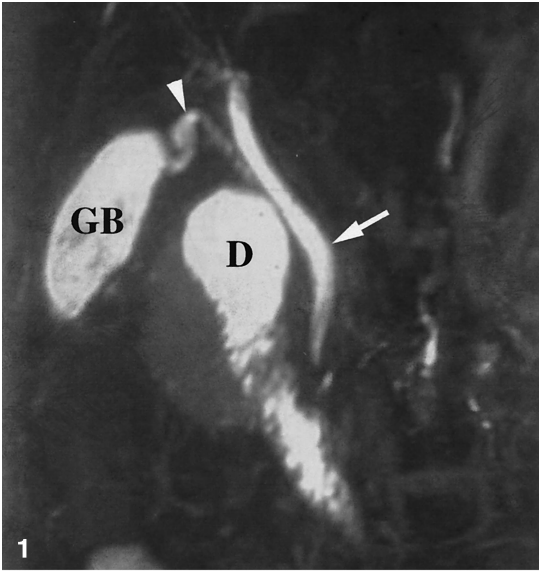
Aberrant hepatic duct and pancreas divisum. Heavily T2-weighted single-shot RARE image. Projectional view of the biliary system as a whole obtained with thick-slice MR cholangiogram demonstrates an aberrant insertion of the posterior right hepatic duct (arrow) and an abnormal insertion of the dorsal pancreatic duct into the duct of Santorini (arrowheads).
